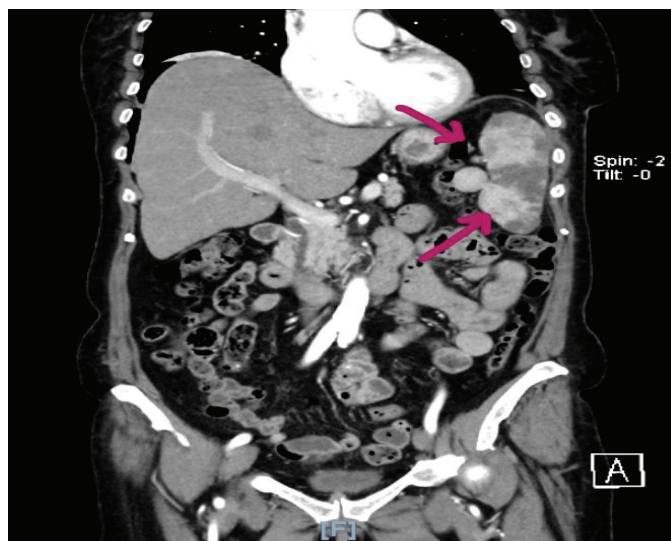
Computed tomography scan showing multiple hypovascular zones in the spleen.
